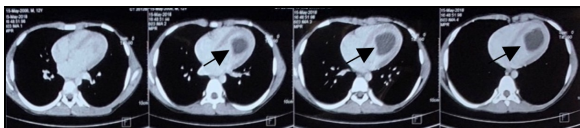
CT scan of chest (transverse section) shows left ventricular cyst
